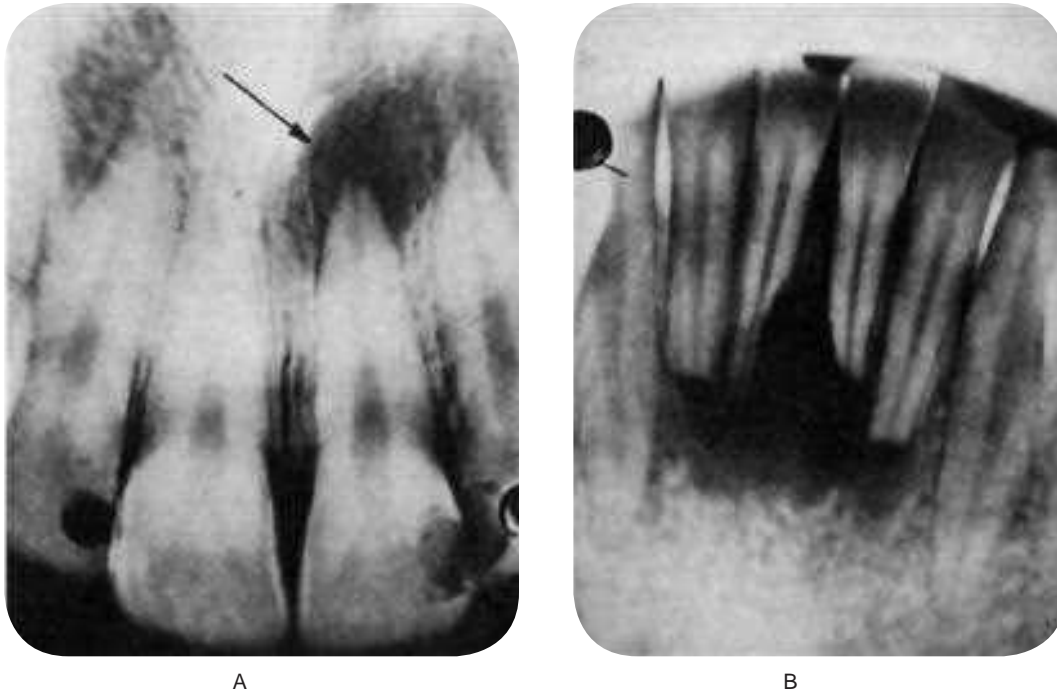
Periapical granuloma.
